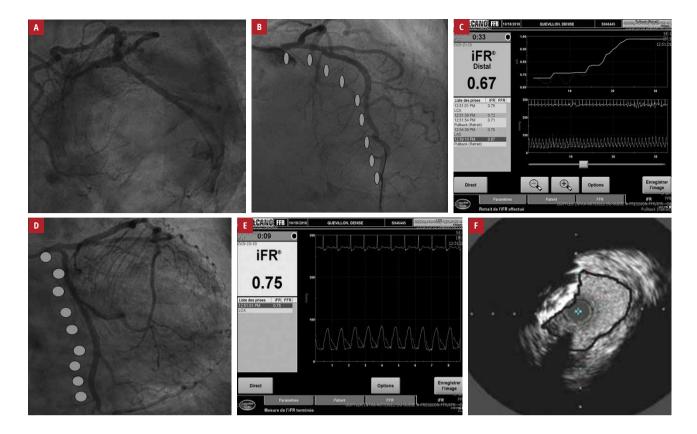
Coronary angiography, hemodynamic data, and adjunctive technologies (instantaneous wave-free ratio [iFR] and intravascular ultrasound [IVUS]) for left main coronary artery (LMCA) disease investigation: \mathbf{A} – a left anterior oblique caudal (spider) view showing nonsignificant plaque of the LMCA ostium; \mathbf{B} , \mathbf{C} – positive iFR measurement in the left anterior descending artery with a pressure increase on the pullback at the LMCA ostium. \mathbf{D} , \mathbf{E} – positive iFR measurement in the circumflex artery with a pressure increase on the pullback at the LMCA ostium. \mathbf{D} , \mathbf{E} – positive iFR measurement in the circumflex artery with a pressure increase on the pullback at the LMCA showing the reduced minimal luminal area at the ostium (5.8 mm²). Ovals in \mathbf{B} and \mathbf{D} indicate the direction of the pullback from distal to proximal.
